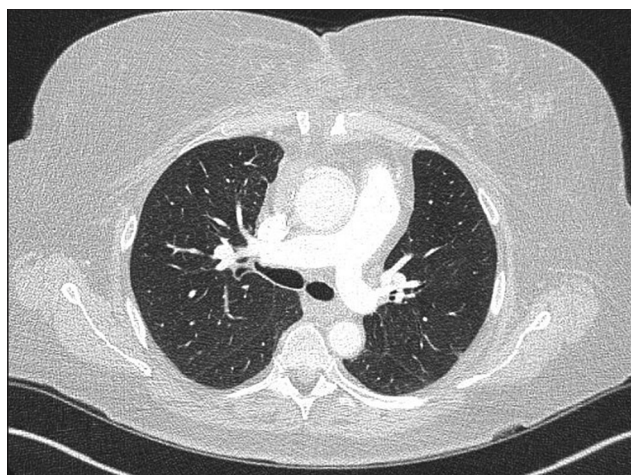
A 3-month follow-up computed tomography of the chest demonstrated a complete resolution of pulmonary infiltrates without sequelae
